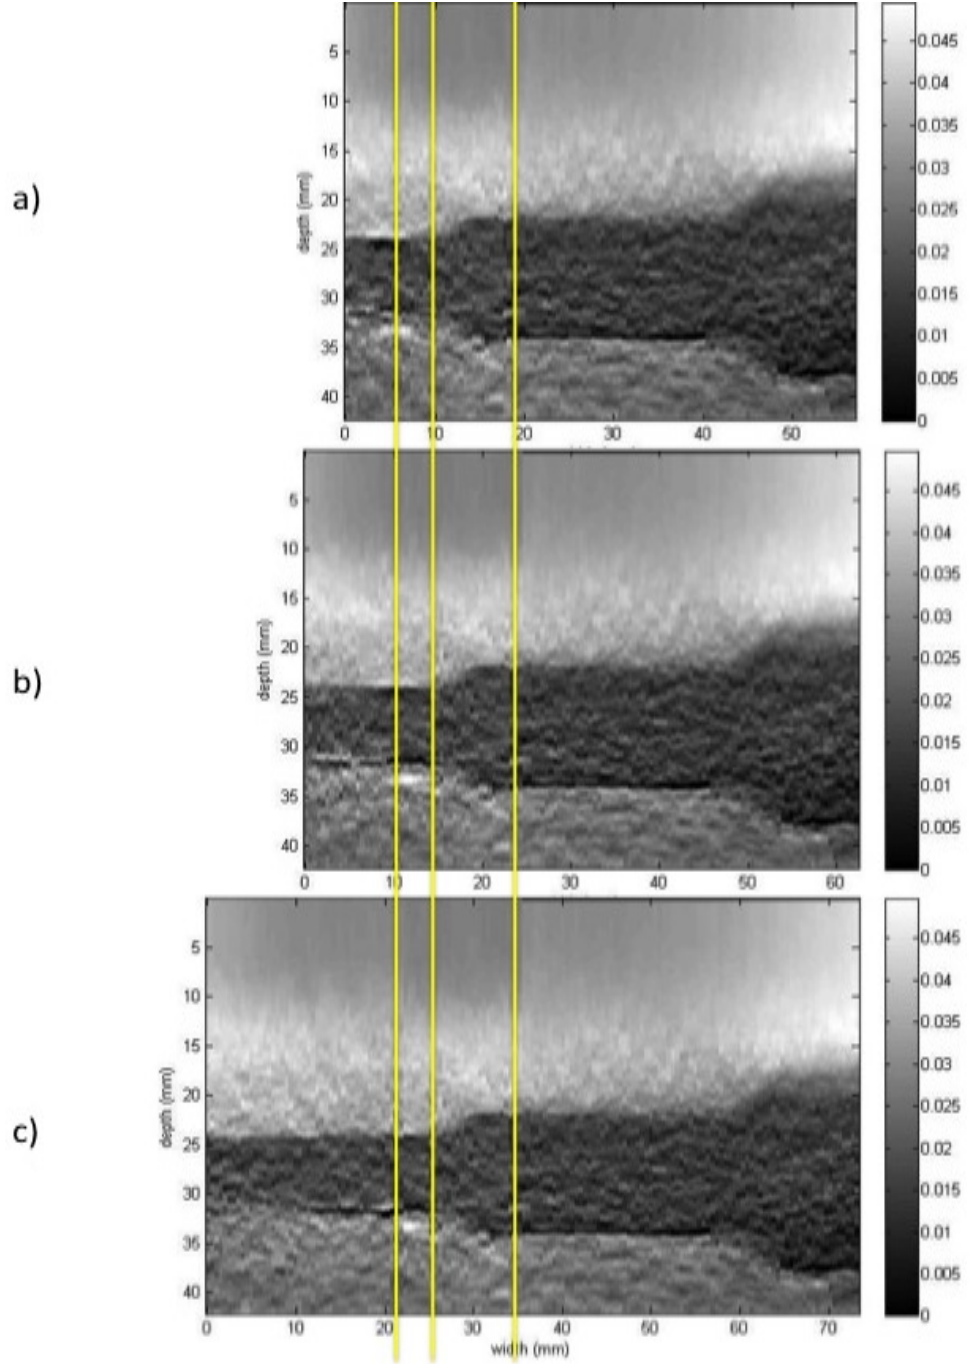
Ultrasound elastography mosaics of positions t_0 and t_1 (a), t_0 , t_1 and t_2 (b), and t_0 , t_1 , t_2 and t_3 (c). Stitching lines are shown in yellow.
